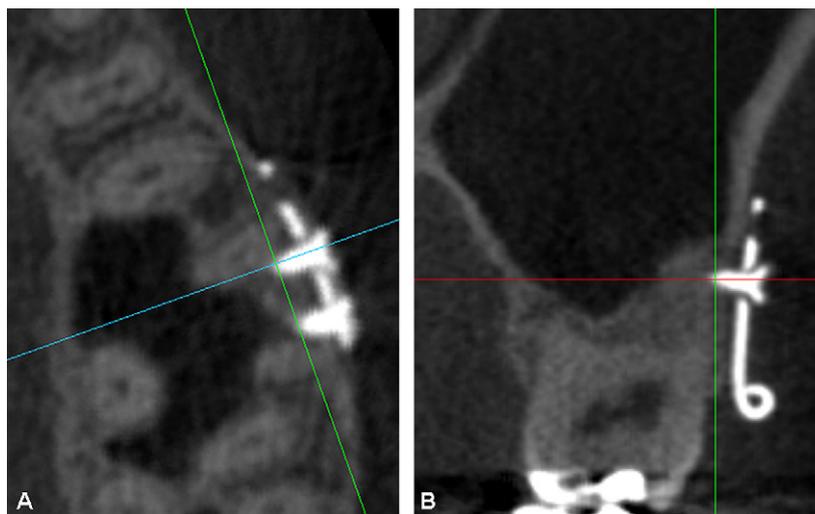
CBCT view of the miniplate confirming root contact with the miniscrew: A, axial view; B, frontal view.
